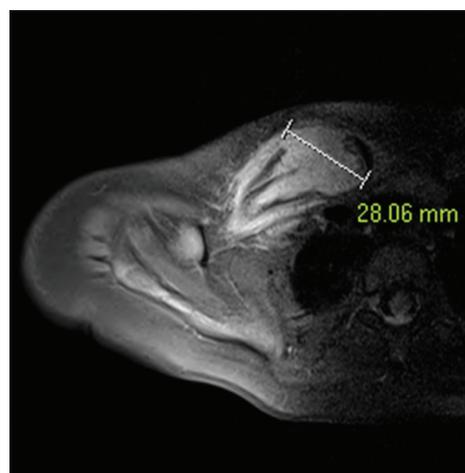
Magnetic resonance imaging reveals a mass in the right proximal clavicle
